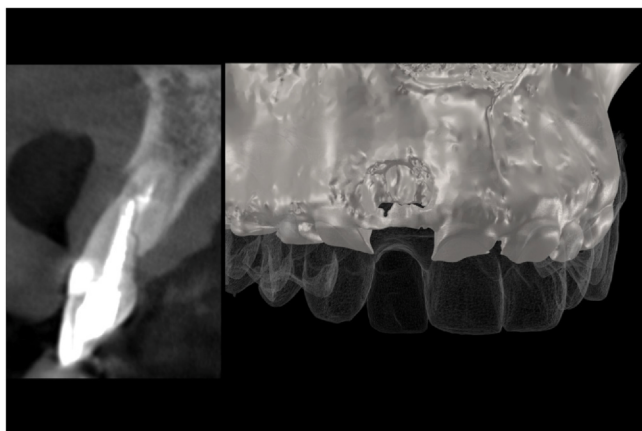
Standard tessellation language (STL) file combining initial situation, prosthetic project, and radiographic imaging revealing labial bone defect.
